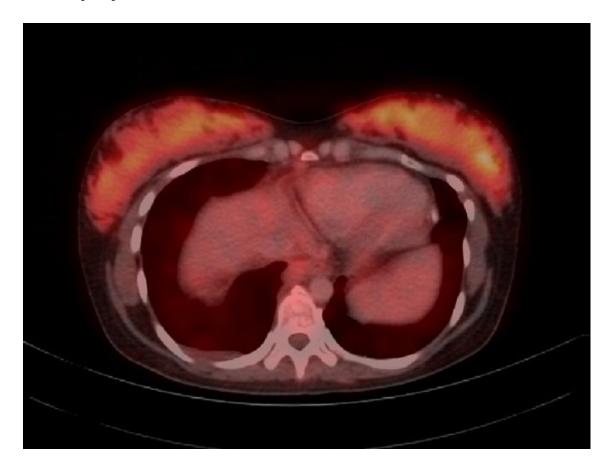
Axial Fluorine-18 (<sup>18</sup>F) FDG PET/CT fusion image [165]
